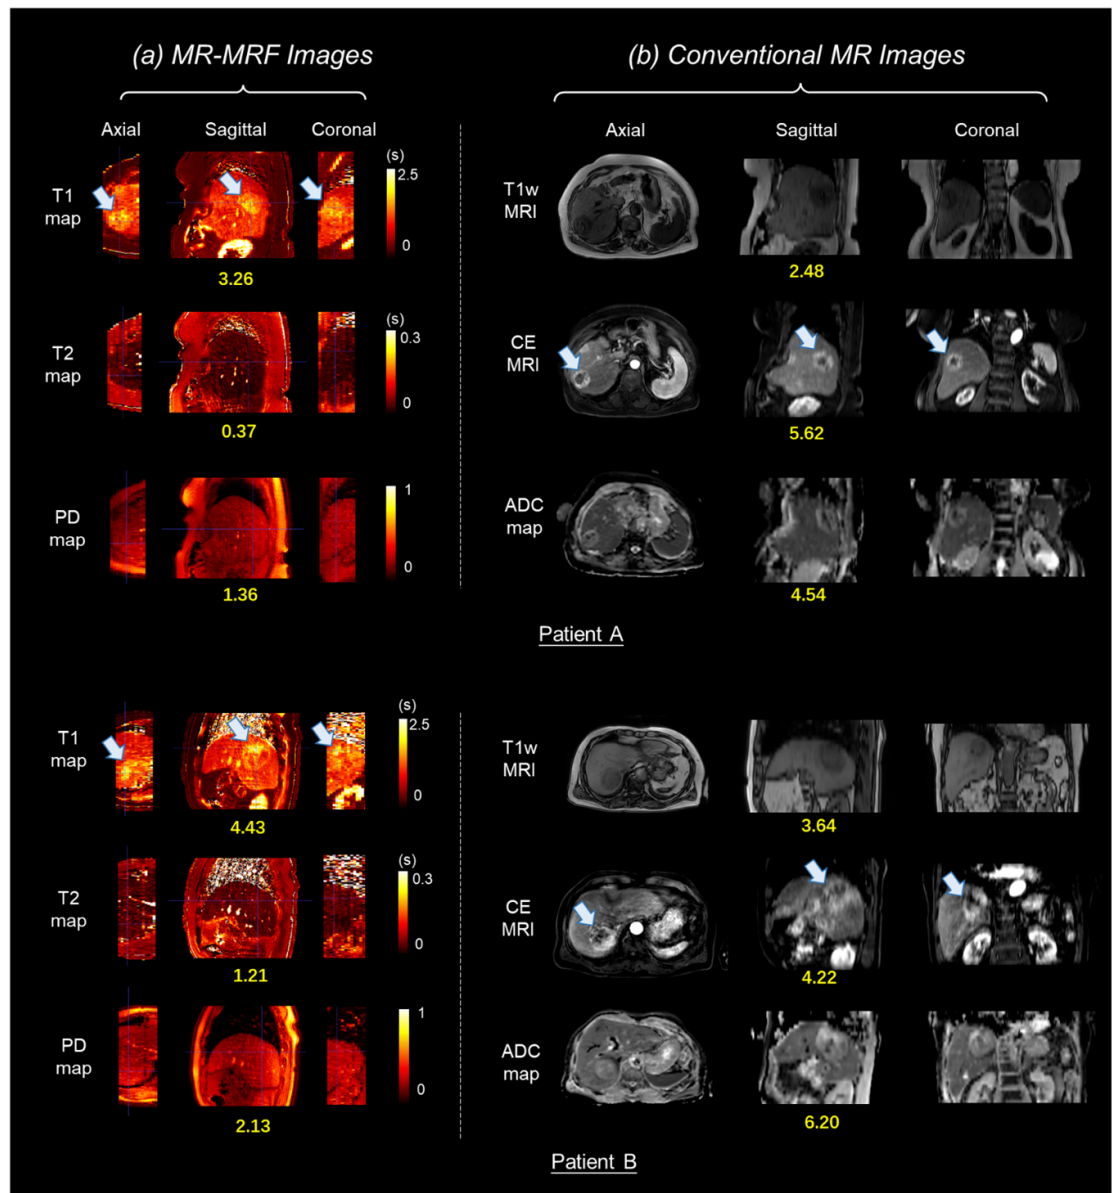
Comparison of MR-MRF quantitative tissue mapping with conventional MRI sequences in hepatocellular carcinoma (HCC). Left: MR-MRF-derived parametric maps (T1, T2, and PD) from two representative HCC patients: (A) 75 year-old male and (B) 87 year-old female. Right: corresponding conventional MRI sequences including (i) T1-weighted imaging, (ii) contrast-enhanced MRI (CE-MRI; arterial phase), and (iii) ADC maps. Tumors are indicated by white arrows (T1 maps, CE-MRI), with adjacent yellow text reporting quantitative tumor-to-liver contrast-to-noise ratios (CNR).
